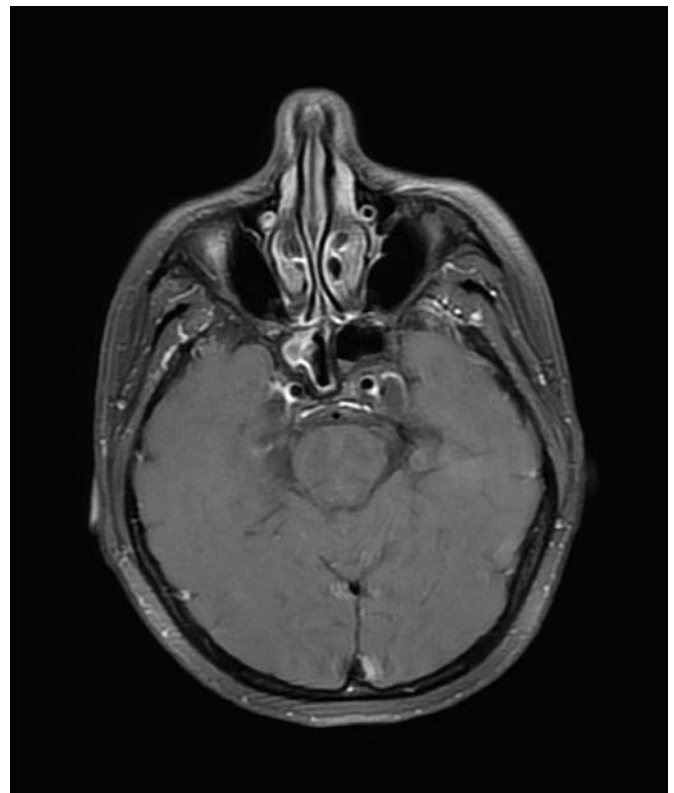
Axial post-contrast T1 weighted magnetic resonance imaging showing hypo- and isointensity.
